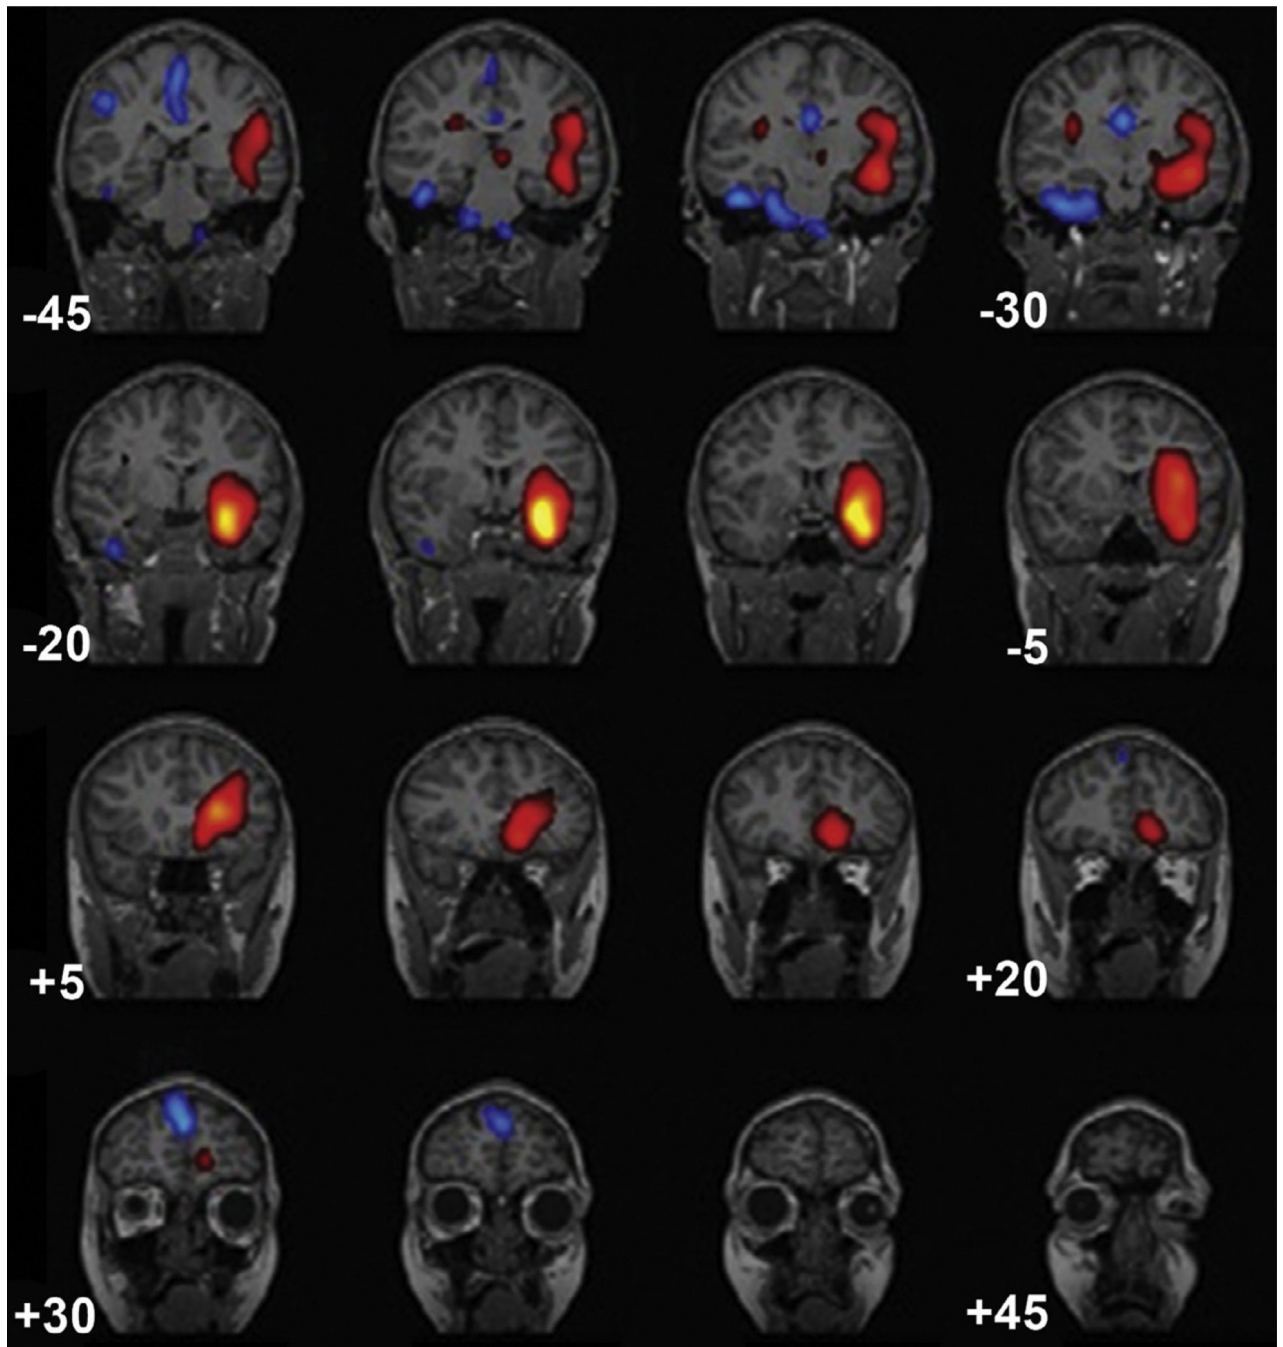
STATISCOM (statistical ictal SPECT coregistered to magnetic resonance imaging) shows a left medial temporal-lobe region of hyperperfusion in a patient with left temporal-lobe epilepsy.
